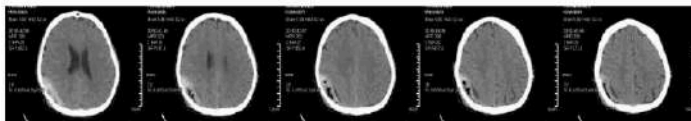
Postoperative head CT scan
